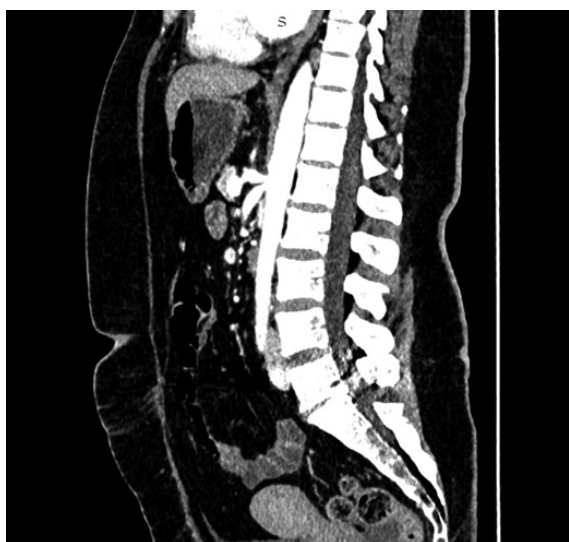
CT of the abdomen, sagittal view
